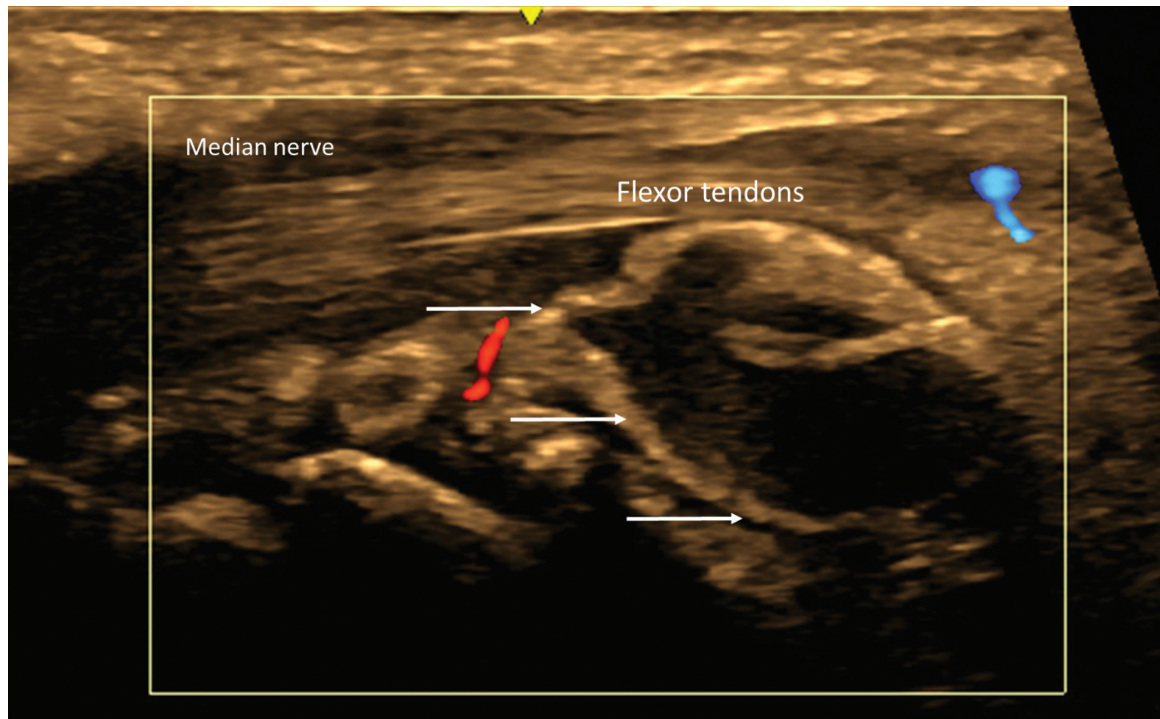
Longitudinal sonographic view of the wrist demonstrating ill-defined, mass-like calcification within carpal tunnel (white arrow), deep to the flexor tendons and median nerve (labeled). No significant vascularity within the calcification. Also note the isoechoic-to-hyperechoic appearance of calcification and absence of any appreciable acoustic shadowing, features which are characteristic of type 3 calcification.
